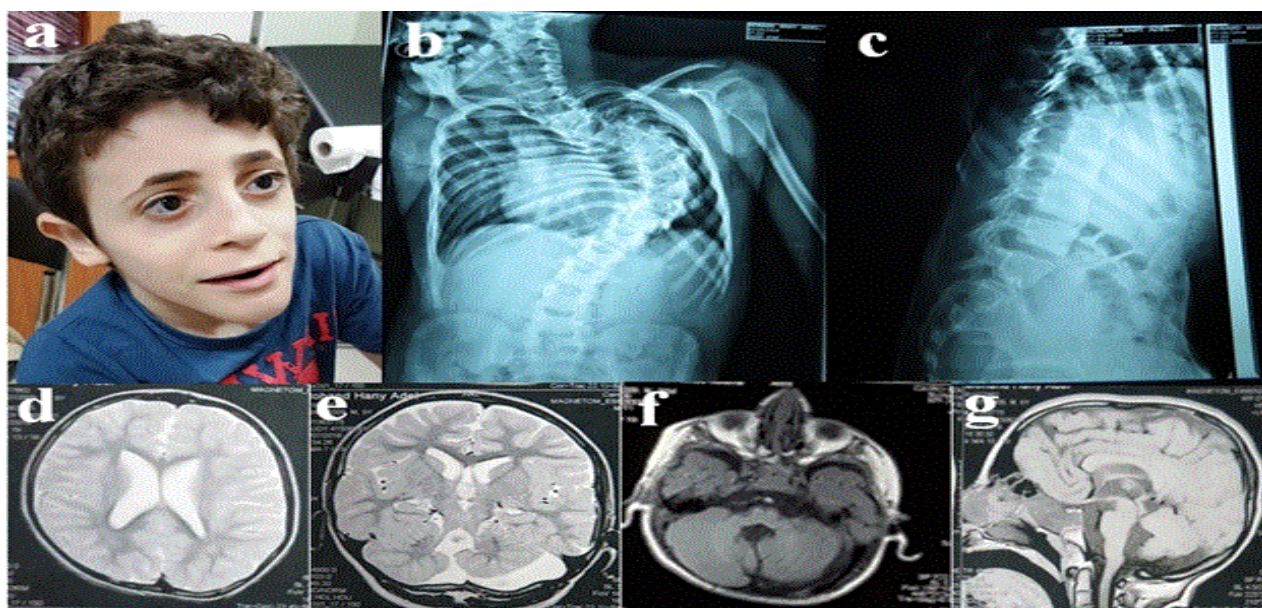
a. The patient's facial feature. b. and c. Chest X ray is showing scoliosis. d, e, f and g. MRI is showing mild ventriculomegaly, absent splenium of corpus callosum, enlarged 4th ventricle, mild vermis hypoplasia and unilateral cerebellar hypoplasia.
